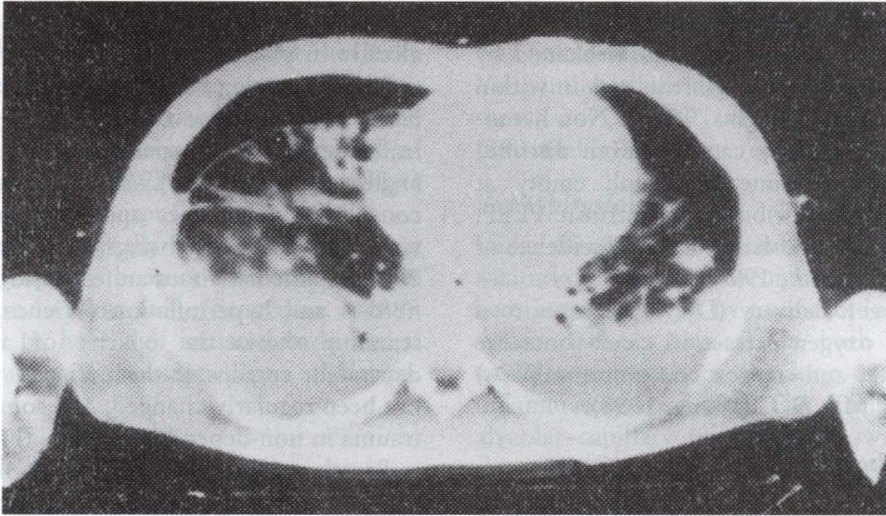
CT scan of a patient with ARDS, showing dense areas of atelectasis in dependent regions and barotrauma represented by a pneumothorax in the right anterior region.
